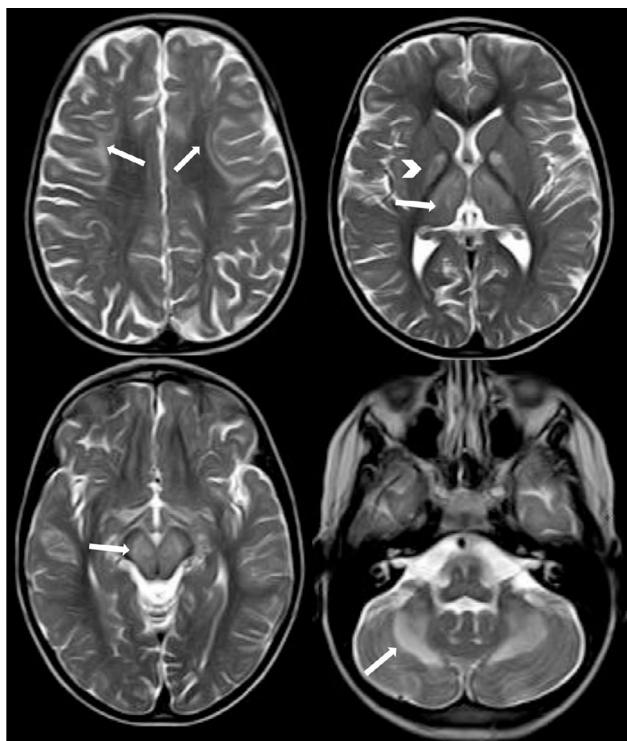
Axial T2-weighted TSE sequence showing signal hyperintensity in the subcortical white matter (U-shaped fibres), which is more pronounced in the frontal lobes (arrows in the upper left image), globi pallidi (arrowhead in the upper right image) and thalami (arrow in the upper right image), brainstem (arrow in the lower left image), and cerebellar white matter, with bilateral, symmetrical involvement.
